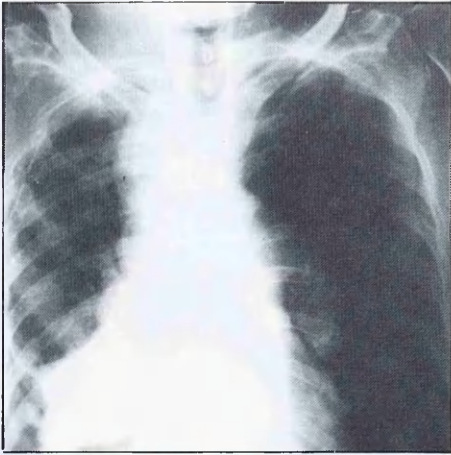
Chest X-Ray after therapy showing resolving of the pleural effusion.
